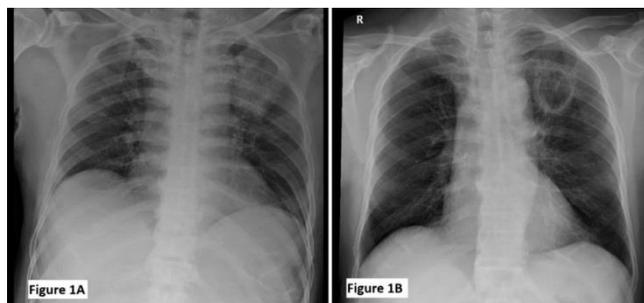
Chest x-ray showing consolidation in left upper zone; A: which has later progressed to a thick walled cavitory lesion B.
